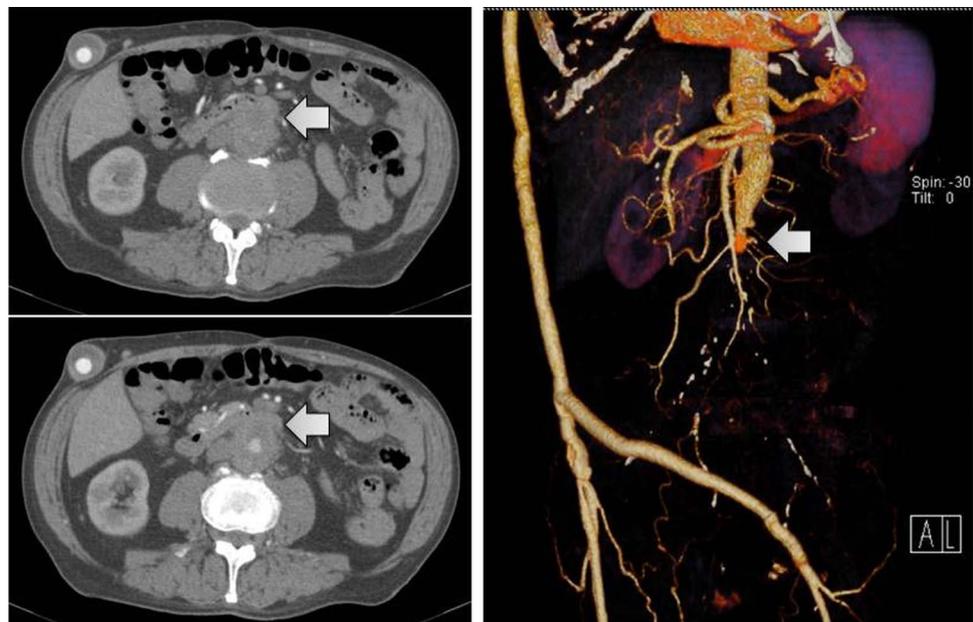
Abdominal CT angiography showing the highly suggestive features of an aortoenteric fistula: proximity between the aortobifemoral bypass graft and the third portion of the duodenum and the effacement of the surrounding fat plane.
